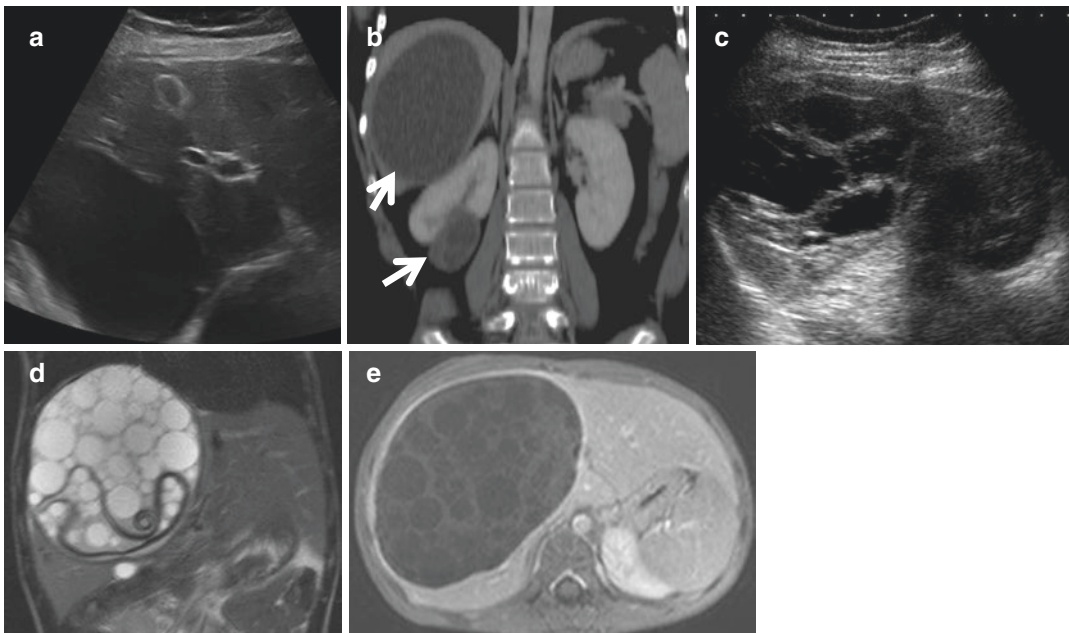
Echinococcal cysts. Nine-year-old girl with abdominal pain (a–c). (a) Liver US shows a simple fluid-filled cysts. (b) On CE-CT both hepatic and renal lesions appear as simple fluid-filled cysts. (c) US performed after percutaneous treatment of the hepatic cyst shows the changes of aspect of the cyst that became multiseptated. In another child, (d, e). (d) MRI with T2-weighted image
